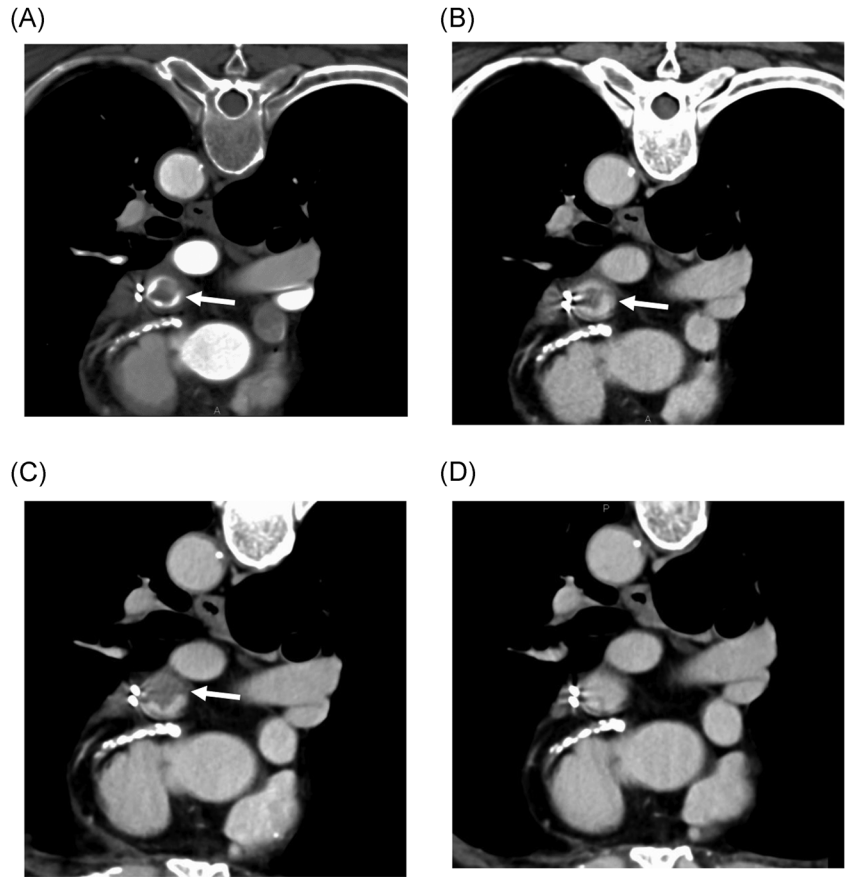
Contrast defect (CD) changes in association with the CT position and scanning phase. This patient was administered apixaban for more than 3 months for persistent atrial fibrillation. Contrast computed tomography (CT) in the supine position was performed, and a CD was detected in both the early and late phases (A) and (B). The patient was intolerant to transesophageal echocardiogram due to difficulties in swallowing the echo probe. A week from CT performed in the supine position, CT in the prone position was performed under the same anticoagulant type and dose conditions. A CD was only detected using CT in the early phase (C), but not in the late phase (D). Arrows show CDs, and arrowheads show residual contrast
